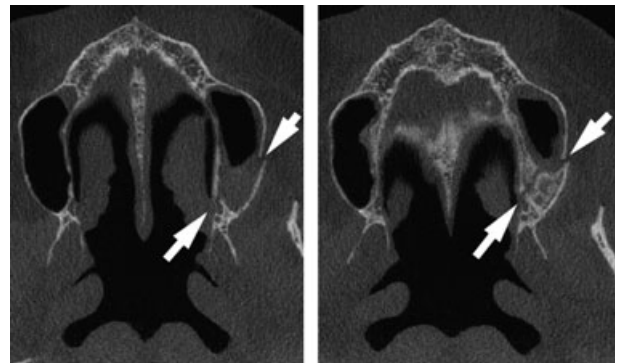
Evidence of fractures (arrows) in the maxillary tuberosity region in computed tomography axial sections.
